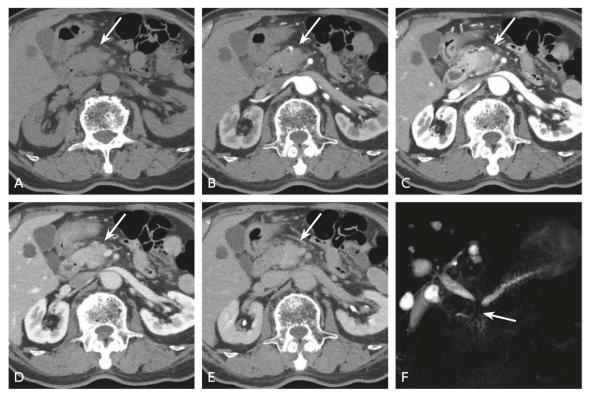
Dynamic CT and MRCP of pancreatic head cancer
